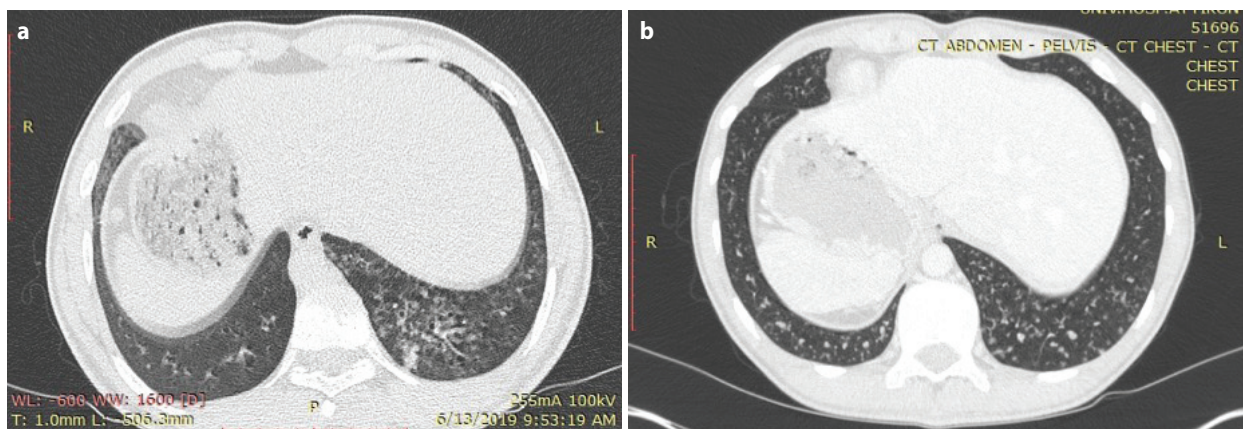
Axial plane chest computed tomography scans revealing bilateral bronchiectasis, with chronic atelectasis in the left “middle lobe” containing bronchiectasis (figure b and c) and an extended tree-in-bud pattern bilaterally (figure a). Pectus excavatum (figure c, d).
